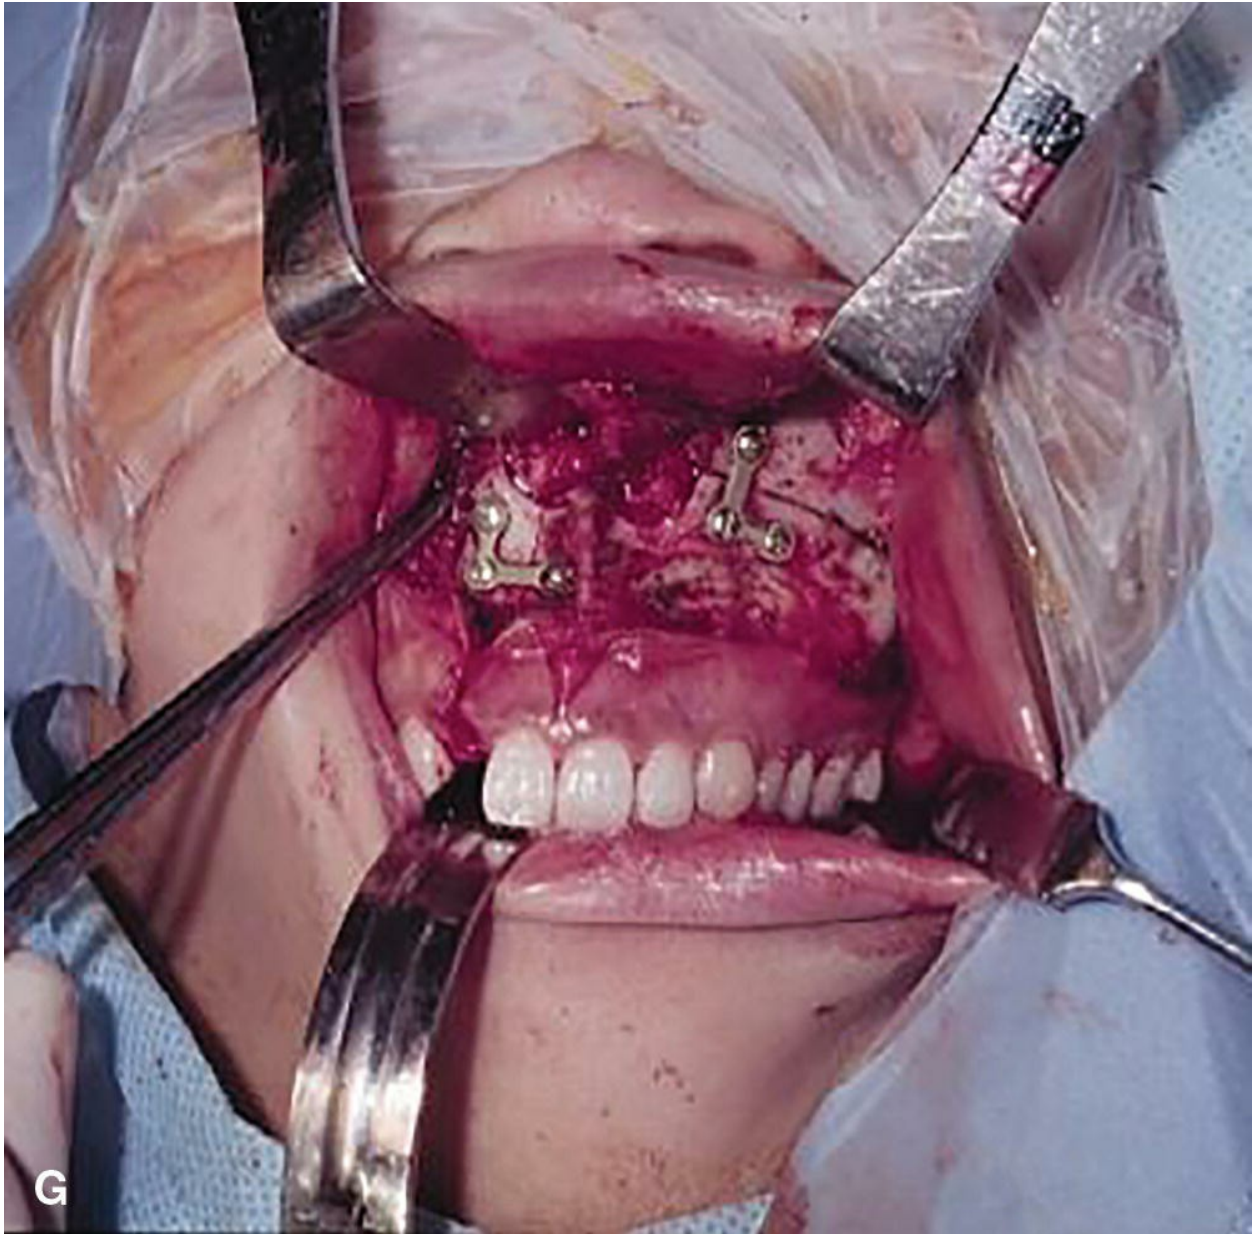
Sublabial approach and inferior maxillotomy for access to sphenoclival region. Preoperative (A, B) and postoperative (C, D) coronal and sagittal MRI of a patient with clival chordoma. E: LeFort I osteotomy (arrow) is done on one side only and connects the pyriform aperture. A second paramedian palatal osteotomy is performed (arrowhead). F: Inferior displacement of the maxilla (maxillotomy) to expose the sphenoid sinus, nasopharynx, and clivus. G: Rigid fixation of the maxillary segments using “pre-registered” titanium microplates to avoid any malocclusion.
